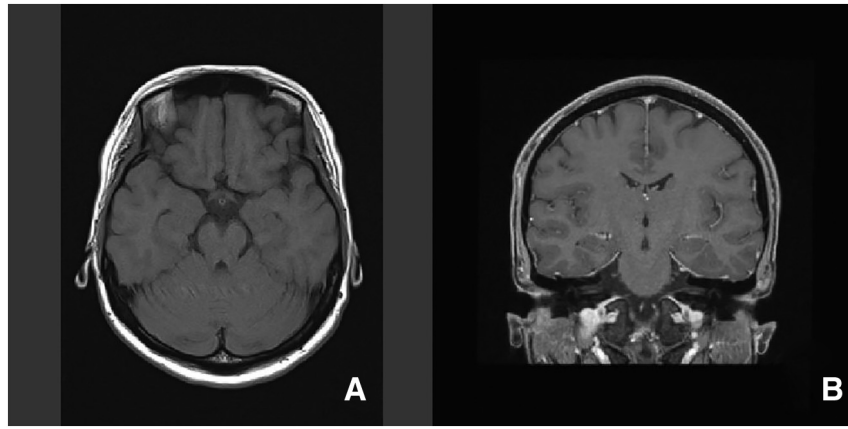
MR images of brain of the patient showing normal findings. A) Axial T1 MRI. B) Coronal T1 MRI.
